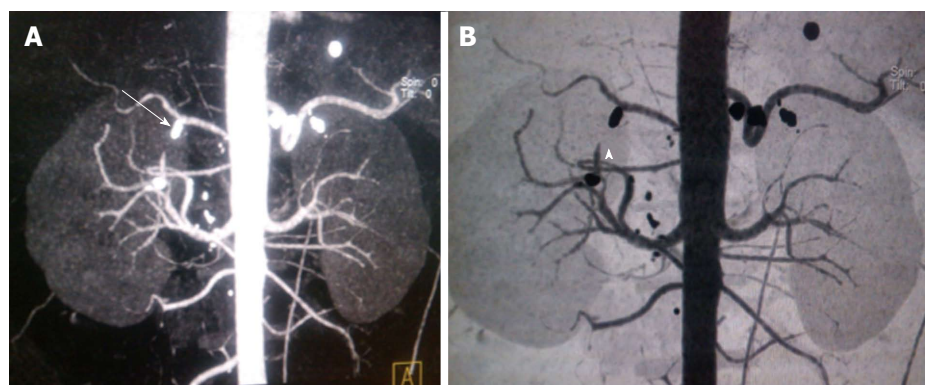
Follow up scan following thrombin injection procedure (case 1). A and B: Coronal MIP (3-D reformatted) CT images. There is non-visualization of the pseudoaneurysm sac (arrowhead, B) with metallic clip (arrow, A) seen at the gastroduodenal artery stump due to previous laparoscopic surgical clipping. CT: Computed tomography; MIP: Maximum intensity projection.
